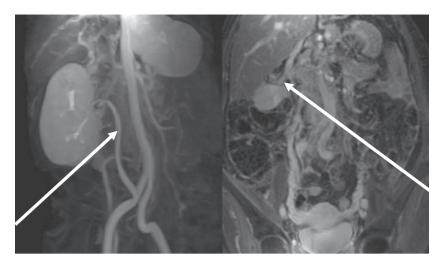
Arterial angiography: arterial inflow, and angio MRI: Venous outflow. The angio MRI indicated proper arterial flow into the transplanted kidney graft and a good venous outflow into the portal vein.
